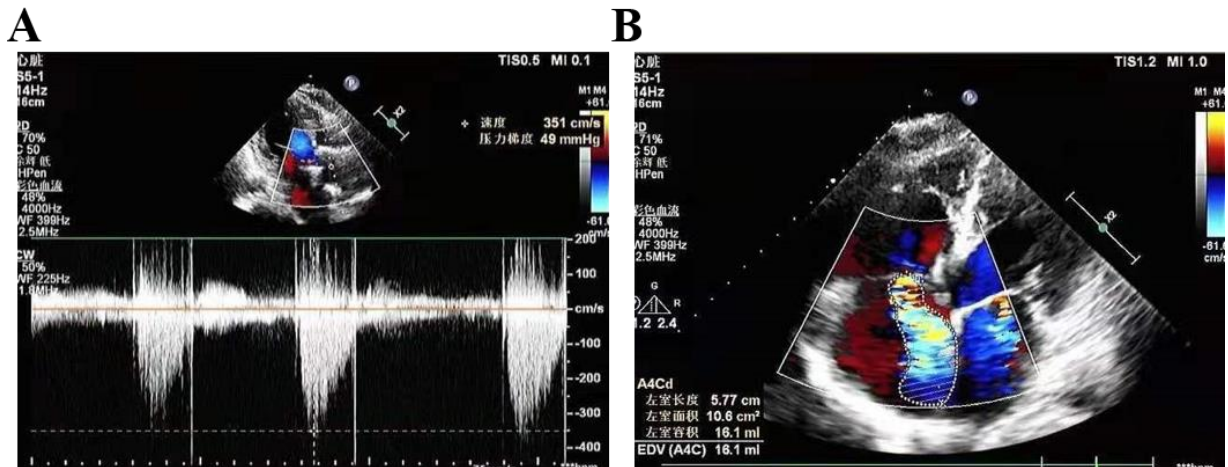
Echocardiography showing pulmonary hypertension (49mmHg), normal size and structures of each cardiac cavity were normal with pulmonary hypertension (A), color flow showing tricuspid regurgitation (B).
